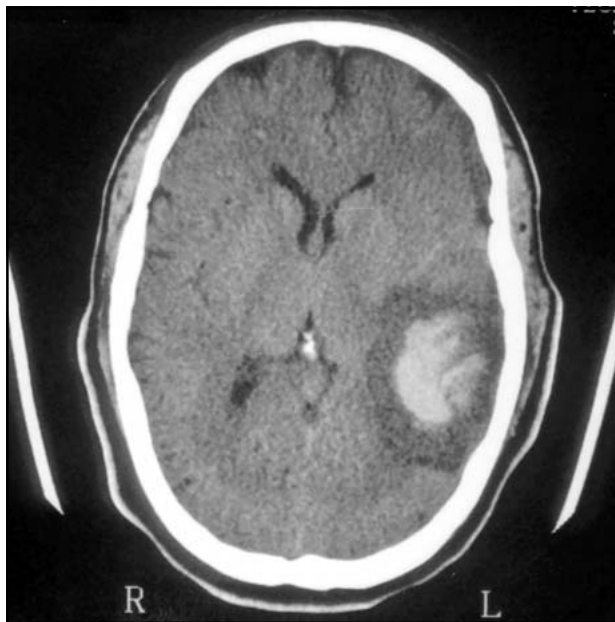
CT scan showing a mass in the left temporal lobe with hemorrhage and edema.
